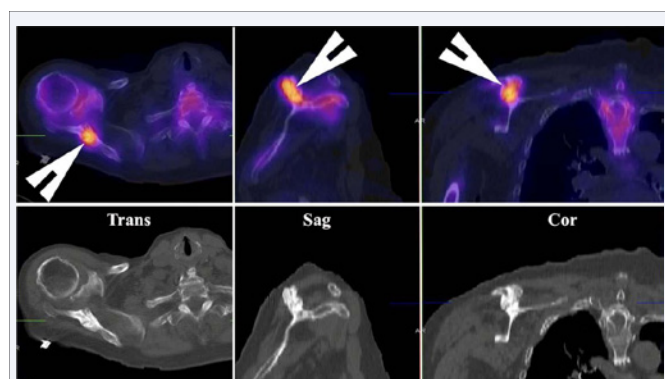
The SPECT/CT images of the right scapula demonstrate intense increase in uptake of tracer in the scapular spine with evidence of a fracture and callus formation (arrowheads). There is uniformly increased uptake of tracer at the fracture site.
